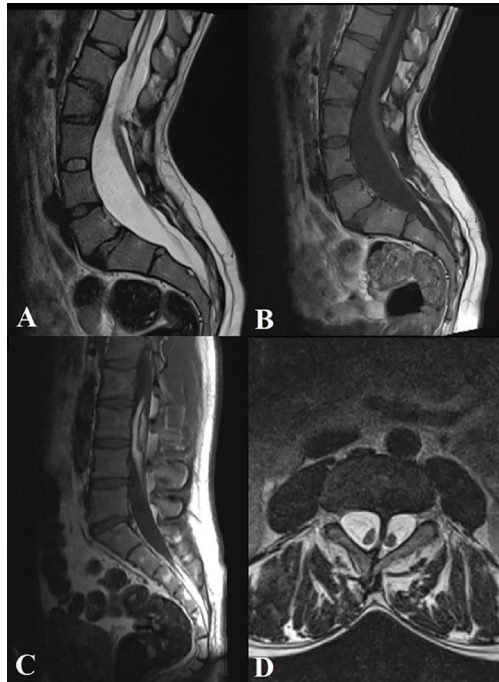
A) Sagittal T2-weighted lumbar MRI demonstrating a low-lying conus, a tight filum terminale, and a syrinx at the T12 level. B) Sagittal T1-weighted images of the same patient showing a fatty filum terminale. C) A filar lipoma at the L3-L4 level contributing to cord tension. D) Axial T2-weighted lumbar MRI revealing a bony septum dividing the spinal canal into two hemicords, consistent with split cord malformation. MRI: Magnetic resonance imaging
